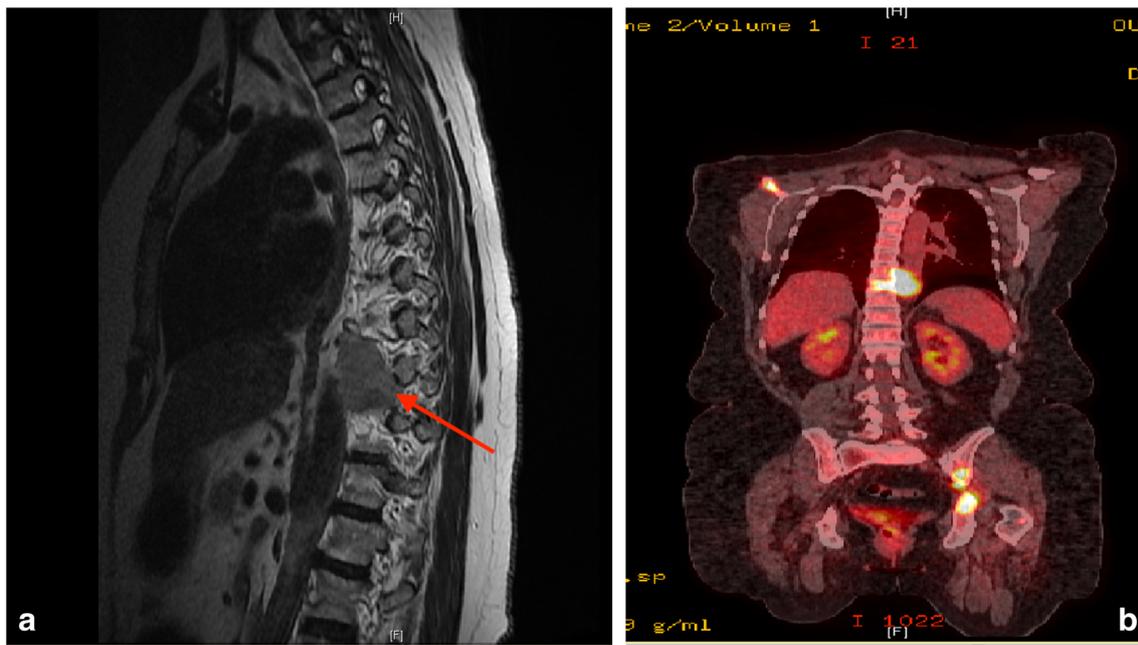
Para-spinal mass at T9 vertebra: a MRI spine, b PET scan
